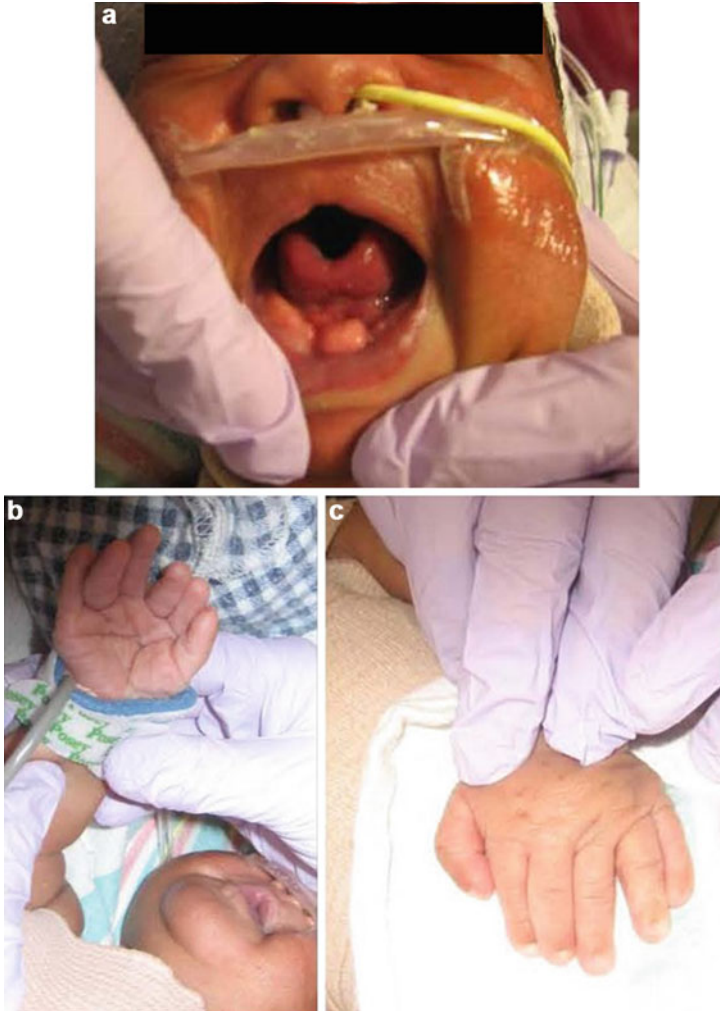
(a–c) A 2-day-old male infant with abnormal fetal ultrasound (our OB) showing short limbs and a complex heart defect with a common atrium and AV canal. The infant showed short stature, short extremities, a long narrow chest, some tethering of the internal upper lip to the gingival margin, oral frenula causing clefting of the upper and lower gingiva (a). The infant has postaxial polydactyly on both hands, hypoplastic nails on both fingers (c) and toes, and distal shortening of the digits of both hands and feet. Cranial and renal ultrasounds were normal. Postnatal
